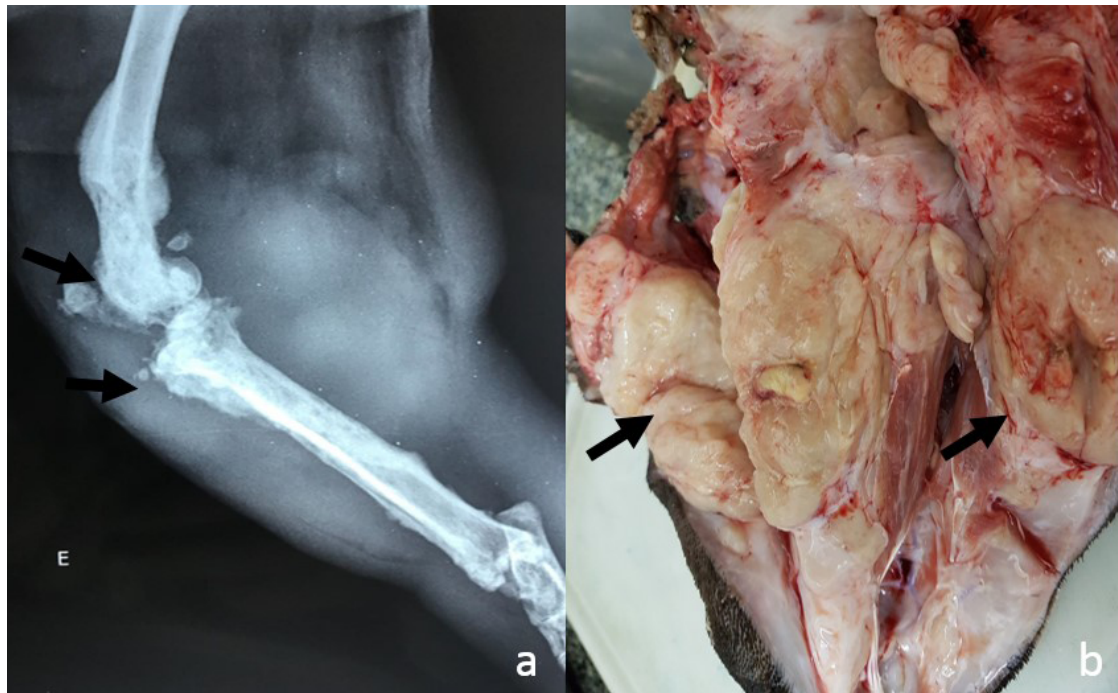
French Bulldog, 11-year-old, left pelvic limb, periarticular histiocytic sarcoma. A- Radiographic aspects: mediolateral radiographic projection showing new bone formation in the distal femur and proximal tibia with soft tissue enlargement (arrow). B- A firm, yellowish-white mass infiltrating the subcutaneous tissue and muscle adjacent to the femur and tibia (arrow).
